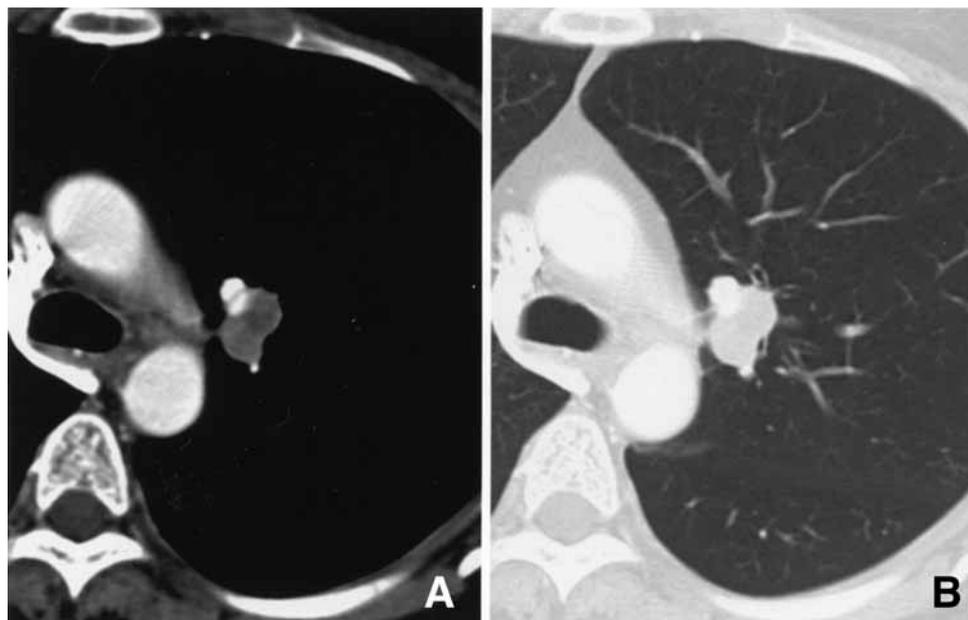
Contrast-enhanced computed tomography (CT) scans of case 2 showing a well-circumscribed nodular shadow in the superior division of the left upper lobe. A: Mediastinal window. B: Lung window.
